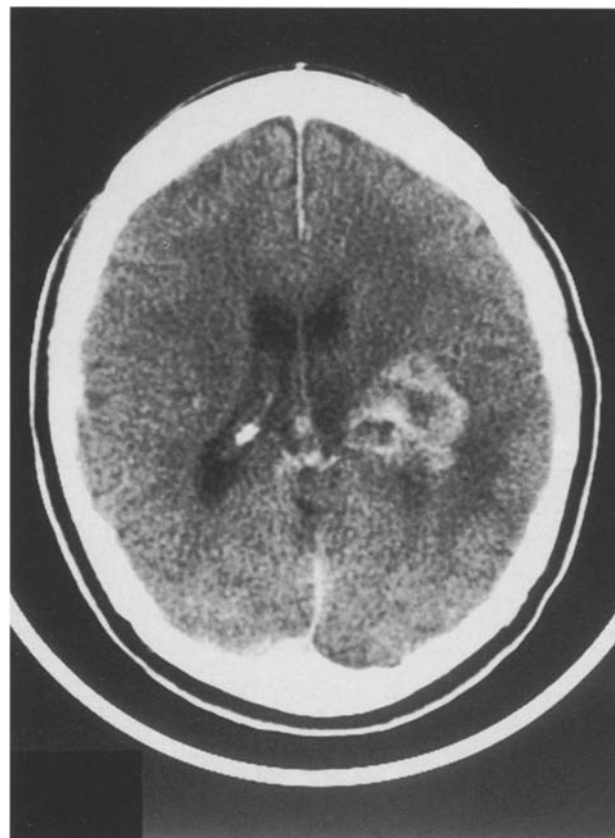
Contrast-enhanced CT scan of head demonstrating an irregularly enhancing deep seated tumor in the left parietal lobe with surrounding edema
